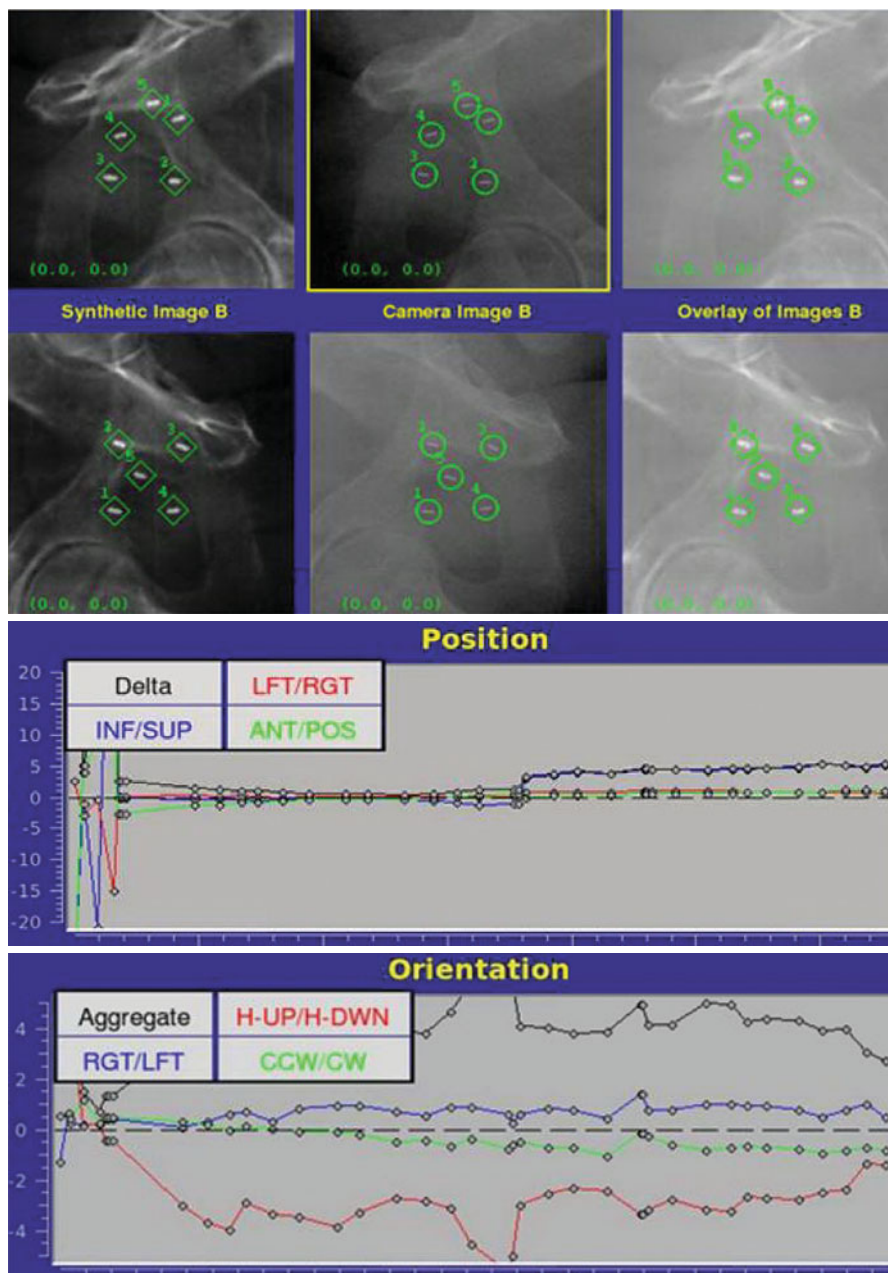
CyberKnife Prostate SBRT Tracking methodology: In this example, 5 transperineally implanted prostate fiducials are three-dimensionally localized by orthogonal images, which are then compared with their computerized digital reconstruction radiograph (DRR) position derived from the CT-based treatment planning images. This overlay process provides full 6-dimensional (translational and rotational) tracking capability. The unique 6-dimensional robotic arm aiming functionality of the CyberKnife device allows automatic correction of tracking error, to fully compensate for all translational and rotational target motion, which makes this a prototypical prostate SBRT device, with end-to-end sub-millimeter targeting accuracy
